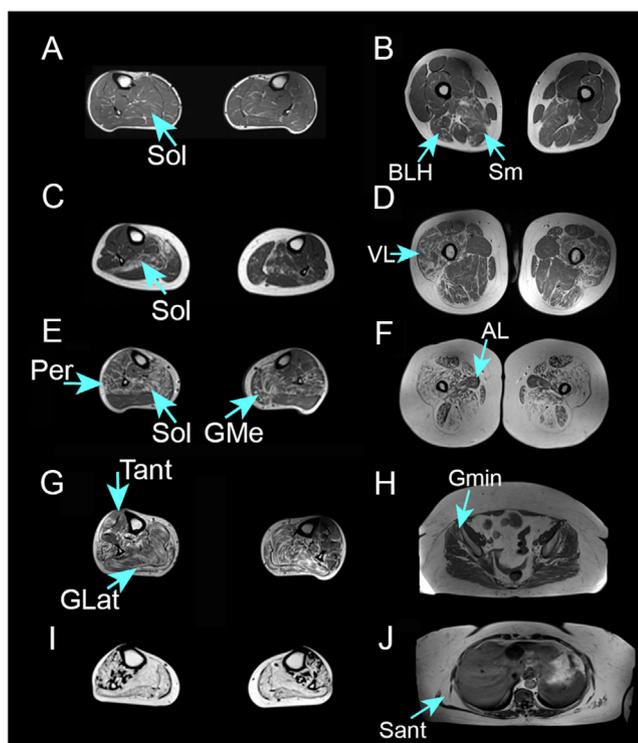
Muscle MRI involvement in patients with mutations in the HSPB1. Upper row shows examples of progressive muscle fatty replacement in five patients. A) Mild isolated involvement of the soleus (arrow). C) Isolated moderate involvement of the soleus (arrow). E) Moderate fat replacement of soleus, peroneus and gastrocnemius medialis (arrows). G) Expansion of the fat replacement to the tibialis anterior and gastrocnemius lateralis (arrows). I) Severe fat replacement of all muscles of the leg. Bottom row show examples of involvement of thigh, pelvis and trunk area. B) Mild fat replacement of the biceps long head (arrow) and semimembranosus (arrow). D) Expansion of the involvement to the vastus lateralis (arrow). F) Severe fat replacement of all muscles of the thigh, except adductor longus (arrow). H) Pelvic involvement showing mild replacement of gluteus minimus (arrow). J) Trunk involvement showing fat replacement of the serratus anterior (arrow). Sol: soleus, Per: peroneus, GMe: Gastrocnemius Medialis, GLat: Gastrocnemius lateralis, Tant: Tibialis anterior, BLH: Biceps Long Head, Sm: semimembranosus, VL: Vastus Lateralis, AL: Adductor longus, Gmin: Gluteus minimus, Sant: Serratus anterior.
